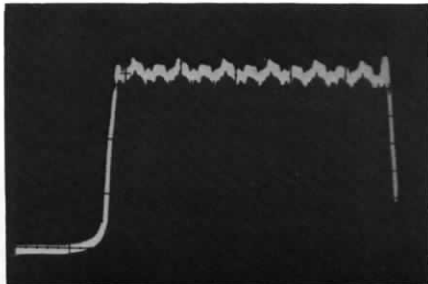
Normal three-phase x-ray output waveform.
